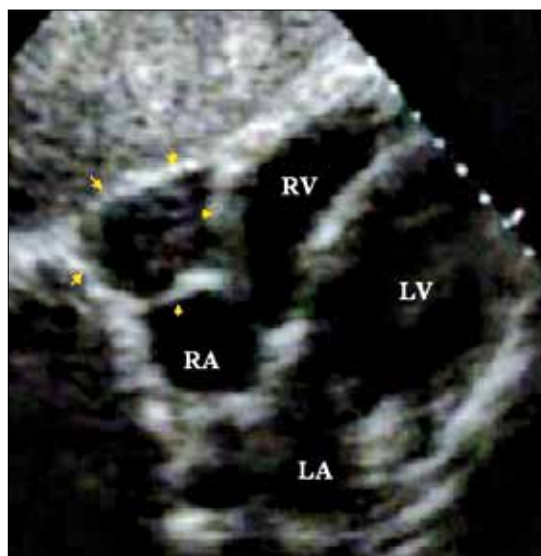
A standard transthoracic echocardiogram from the subcostal approach shows a cardiac mass close to the right atrium (yellow arrows).
